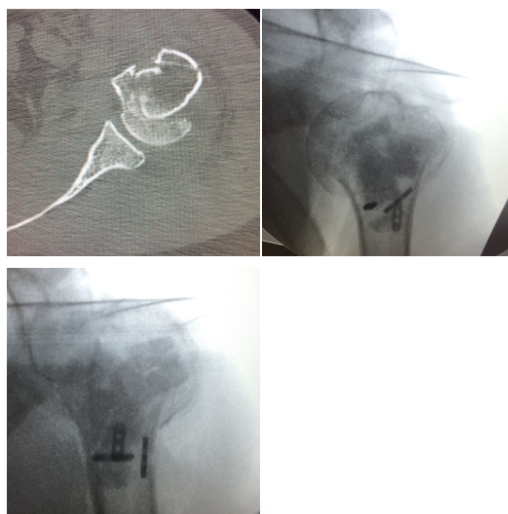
A. Three parts fracture: CT scan; B/C. Radiographic post operative evaluation.
